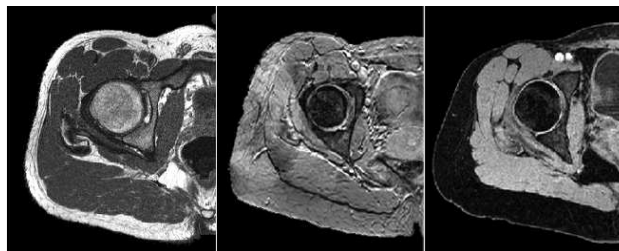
Different MRI sequences for imaging the hip: a) Spin-Echo T1, TR=578ms, TE=18ms; b) Gradient-Echo T2\*, TR=30ms, TE=14ms; c) Gradient-Echo T1, TR=20ms, TE=7ms
